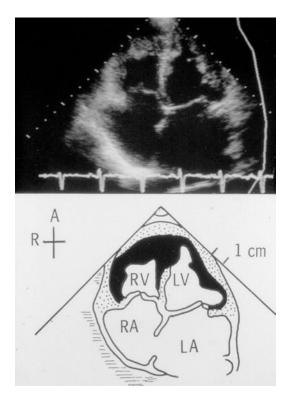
Apical four-chamber view from a patient with endomyocardial fibrosis. Note the packing of the left and right ventricular apex and the marked dilatation of the atria
